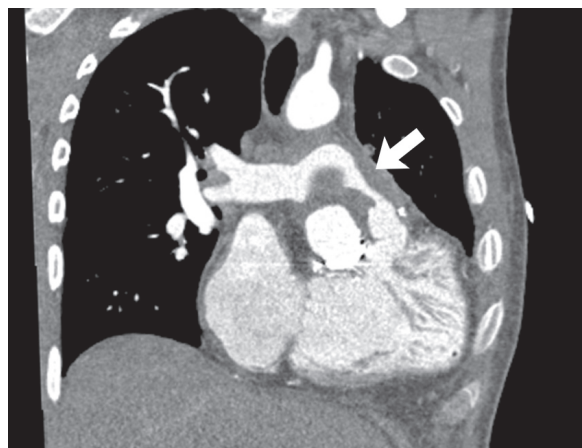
Patch A, on RVOT evaluated with cardiac CT (3D volume rendering reconstruction).
